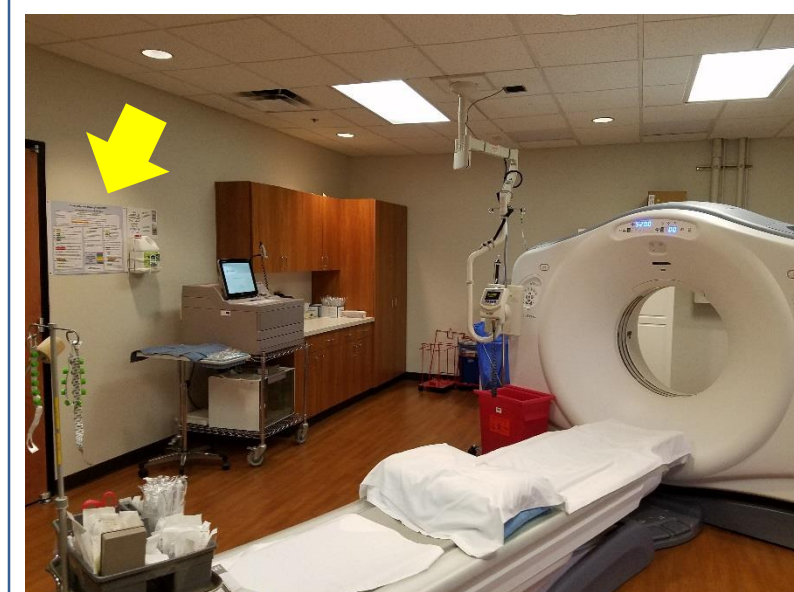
Poster (arrow) placed in CT room
